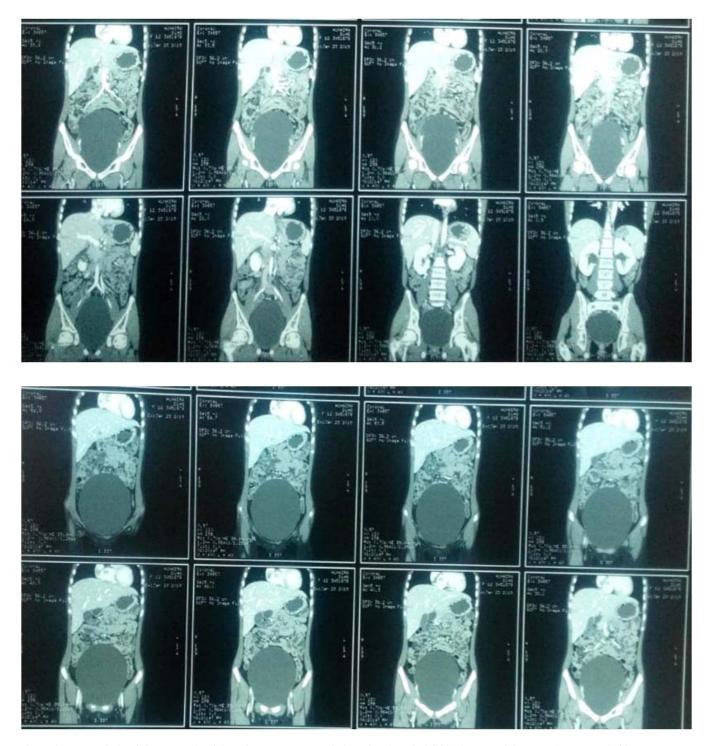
CT scan whole abdomen and pelvis with contrast coronal view showing cholelithiasis, rest of the scan is unremarkable
